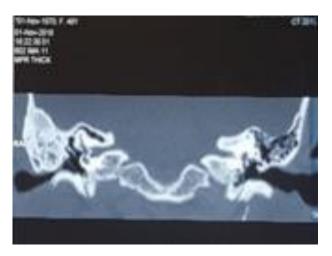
HRCT temporal bone showing sclerotic bony expansion involving mastoid and tympanic portion on right side.
